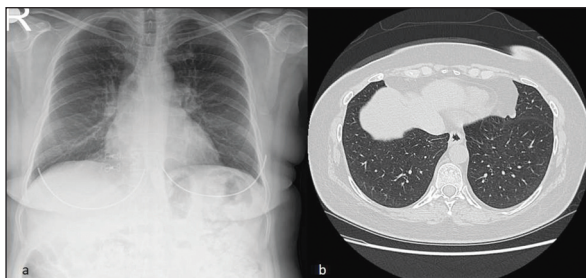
Radiological images of the case a) Postero-anterior chest radiography b) High resolution lung tomography.
